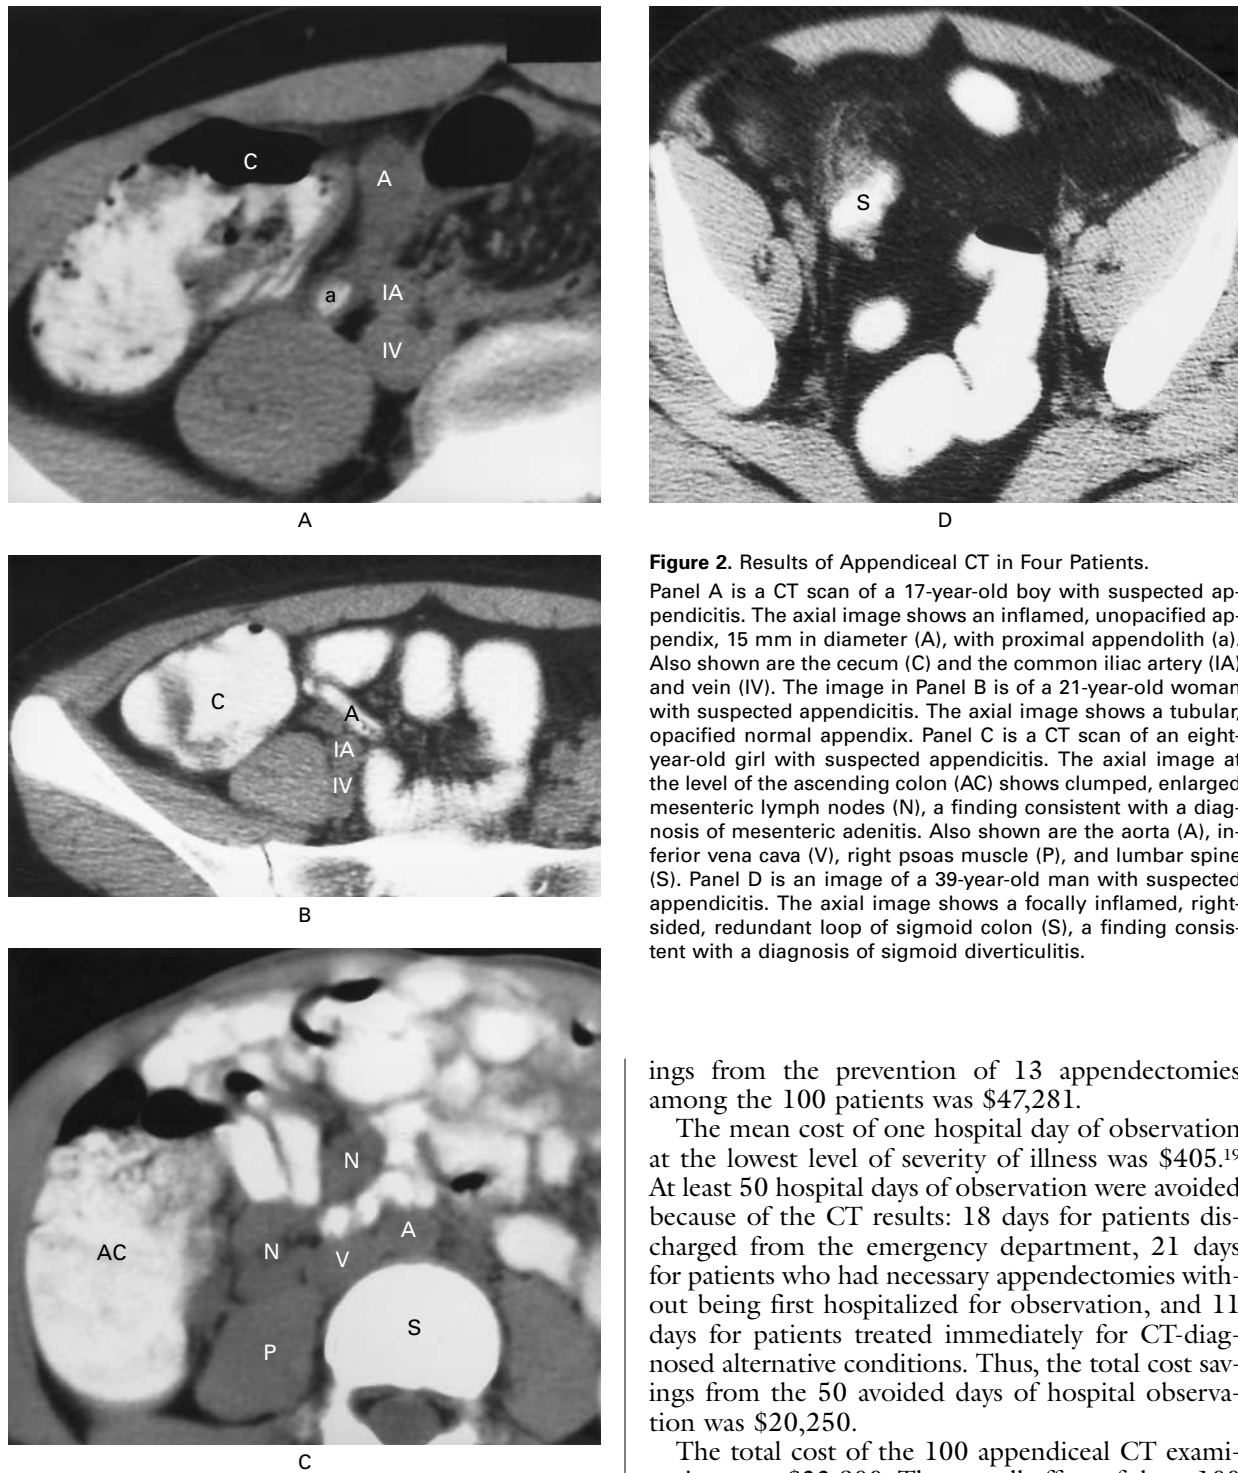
Results of Appendiceal CT in Four Patients.
